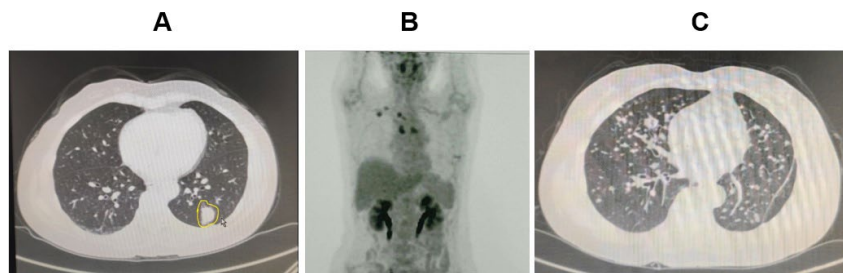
The change of tumor burdens at various time points for Case 1. Panel A shows the primary tumor (in the yellow circle) at the time of diagnosis by CT imaging. Panel B shows PET-CT detection of the initial recurrence after 27 months following the removal of primary tumor. Panel C shows the development of multiple lung metastases after repeated use of anti-PD1 antibody by CT imaging.
